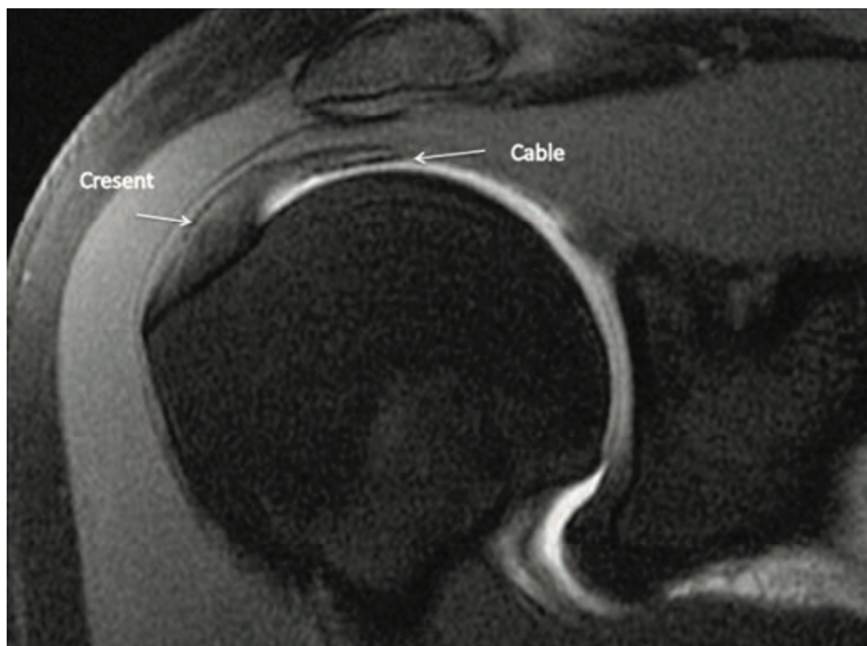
An oblique coronal fat-suppressed T1-weighted imaging from an MR arthrogram shows a normal supraspinatus cable and crescent. (2)
